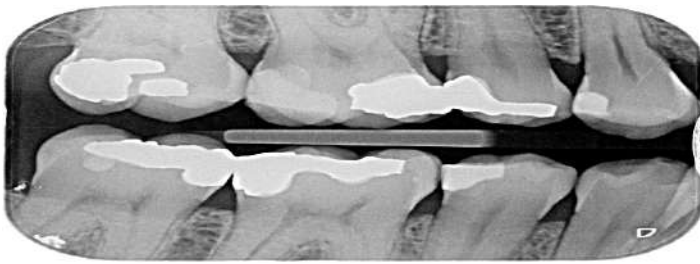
Right bitewing.
